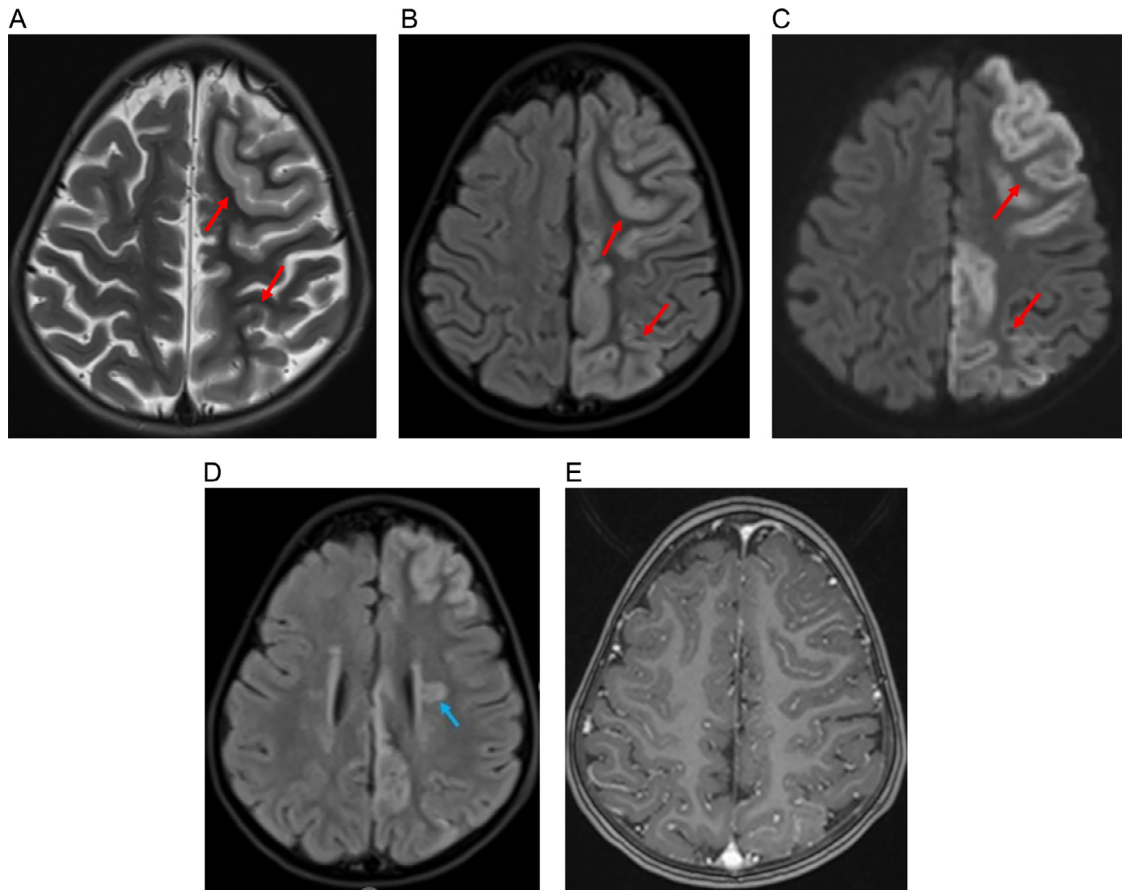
Axial MRI images in T2 (A), FLAIR (B and C), diffusion (D), and postgadolinium contrast (E) sequences reveal signal abnormalities in the left fronto-parietal cortico-subcortical regions (red arrows) and the left periventricular white matter (blue arrow). These abnormalities appear hyperintense on T2 and FLAIR sequences, exhibit restricted diffusion, and do not enhance after Gadolinium injection.
